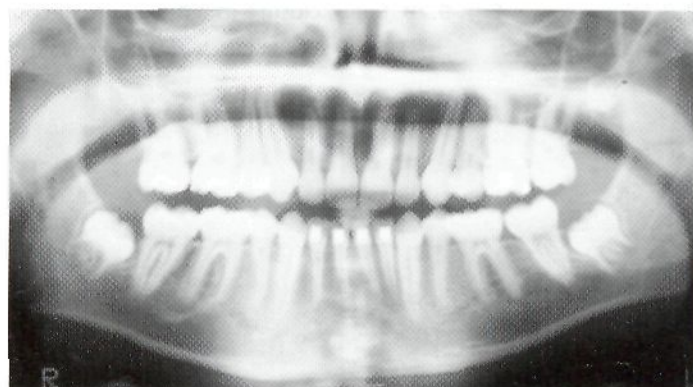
'Before' and 'after' radiographs of a second premolar extraction case. Mesial movement of lower first molars has created space for second and third molars.
